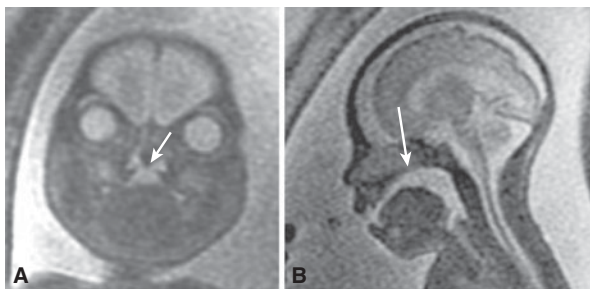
Same case as in Figure 16–11. MRI effectively confirms the central defect in the posterior palate (arrows) both in the coronal plane (A) as well as sagittal plane (B). (Reproduced, with permission, from Benacerraf BR, Sadow PM, Barnewolt CE, Estroff JA, Benson C. Cleft of the secondary palate without cleft lip diagnosed with three-dimensional ultrasound and magnetic resonance imaging in a fetus with Fryns' syndrome. *Ultrasound Obstet Gynecol.* 2006;27[5]:566–570.)
